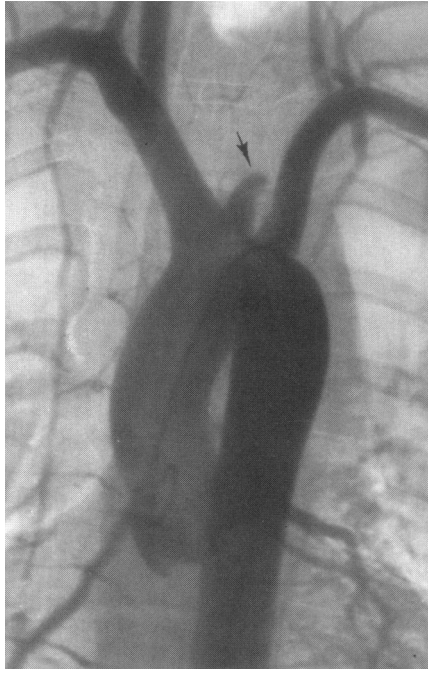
This thoracic aortogram was performed in a 21-year-old man who presented to the Emergency Room following massive blunt trauma to the anterior thorax in an automobile accident. The patient was asymptomatic neurologically and had minimal mediastinal widening on the admission chest radiograph. The aortogram demonstrated a complete interruption of the proximal left carotid artery (black arrow).
